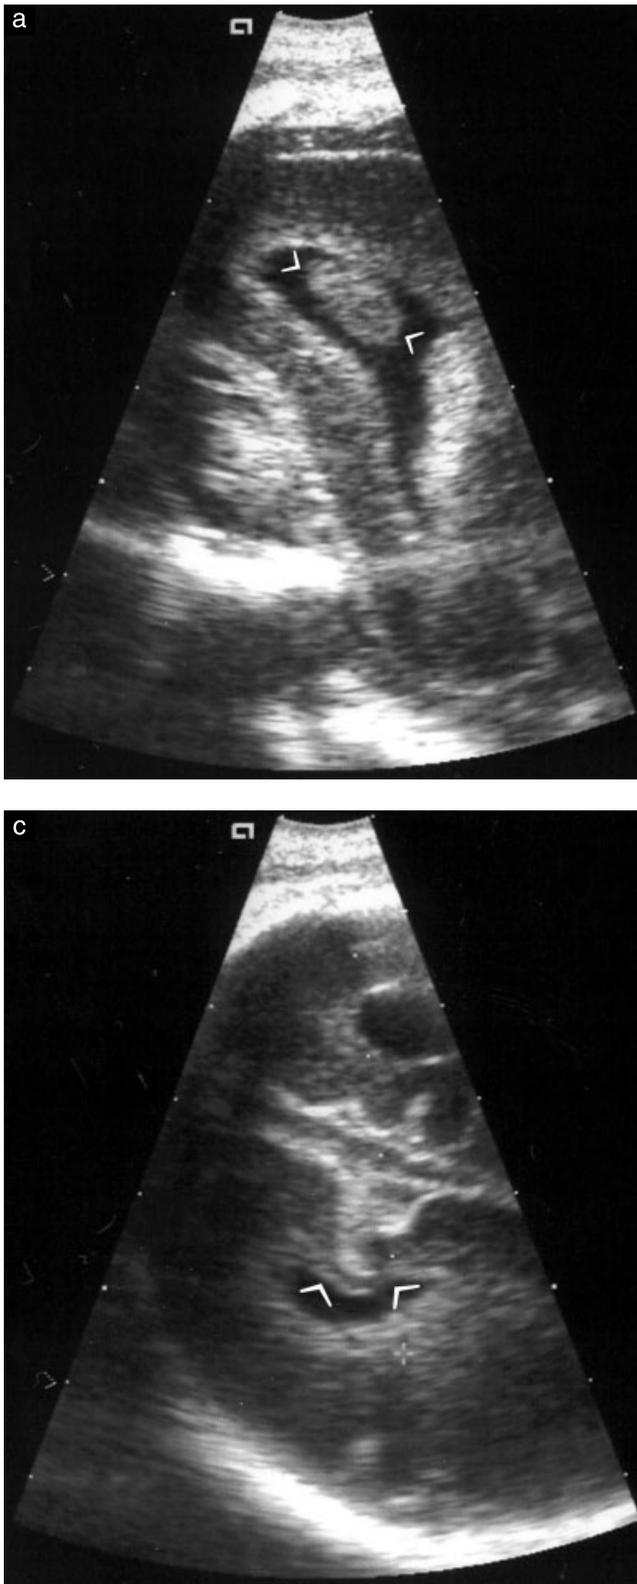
Case 2. (a) Transvaginal ultrasound image at 28 weeks of gestation: parasagittal plane showing an echogenic focus (arrowheads) visualized within the occipital horn of the right lateral ventricle, mimicking an intraventricular clot. (b) In a more medial parasagittal plane the configuration of the calcar avis (arrowheads) could be clearly delineated. (c) The coronal plane showed the right calcarine fissure and the prominent calcar avis (arrowheads).
